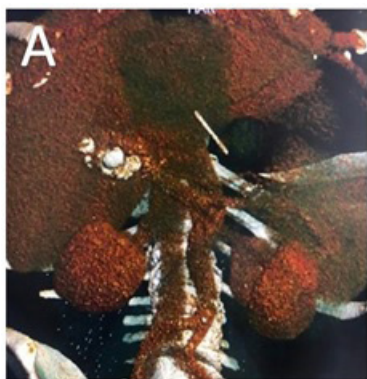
A: Abdominal CT, 3D reconstruction, confirming the presence of a 4 cm long foreign body that perforates the anterior wall of the antrum-pyloric region and introduces 1cm into the left hepatic lobe, corresponding to the origin of the infection.
